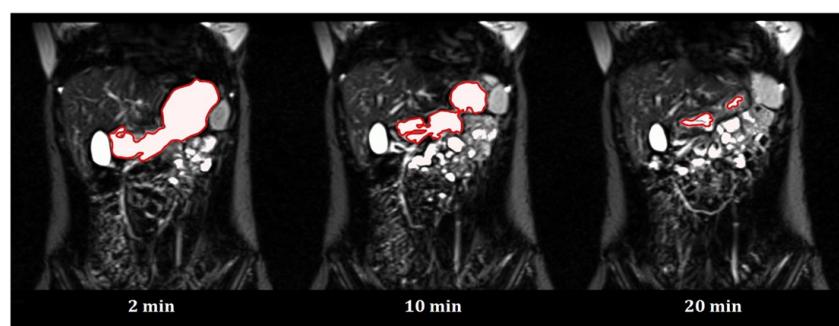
MRI sequences demonstrating rapid gastric emptying of 240 mL water administered in the fasted state. Water inside the stomach is delineated by the red line. Left: 2 min—177 mL; middle: 10 min—120 mL; right: 20 min—4 mL.
